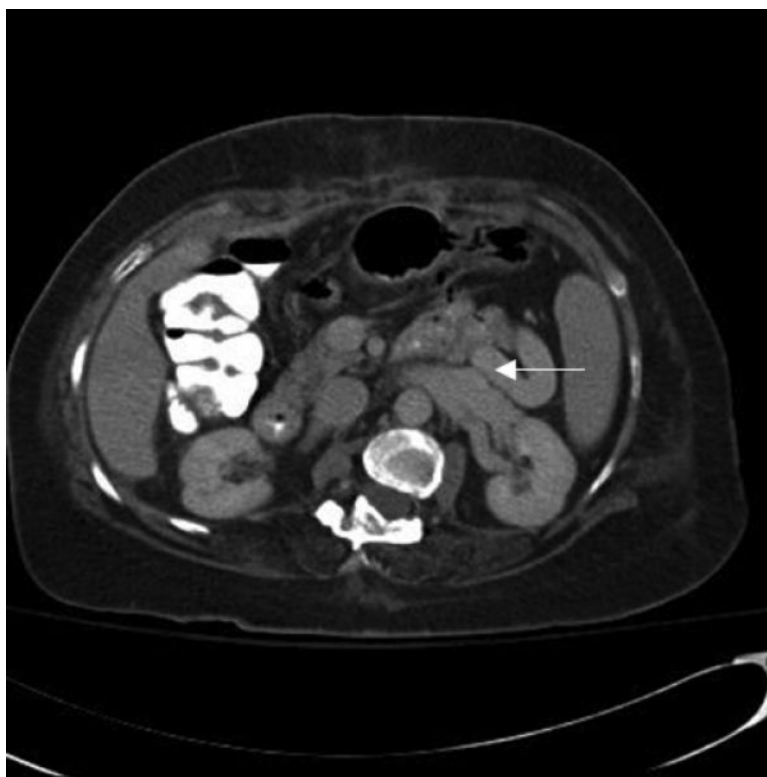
CT scan demonstrating a left renal vein to inferior mesenteric vein shunt via tortuous gonadal vein (single arrow).
